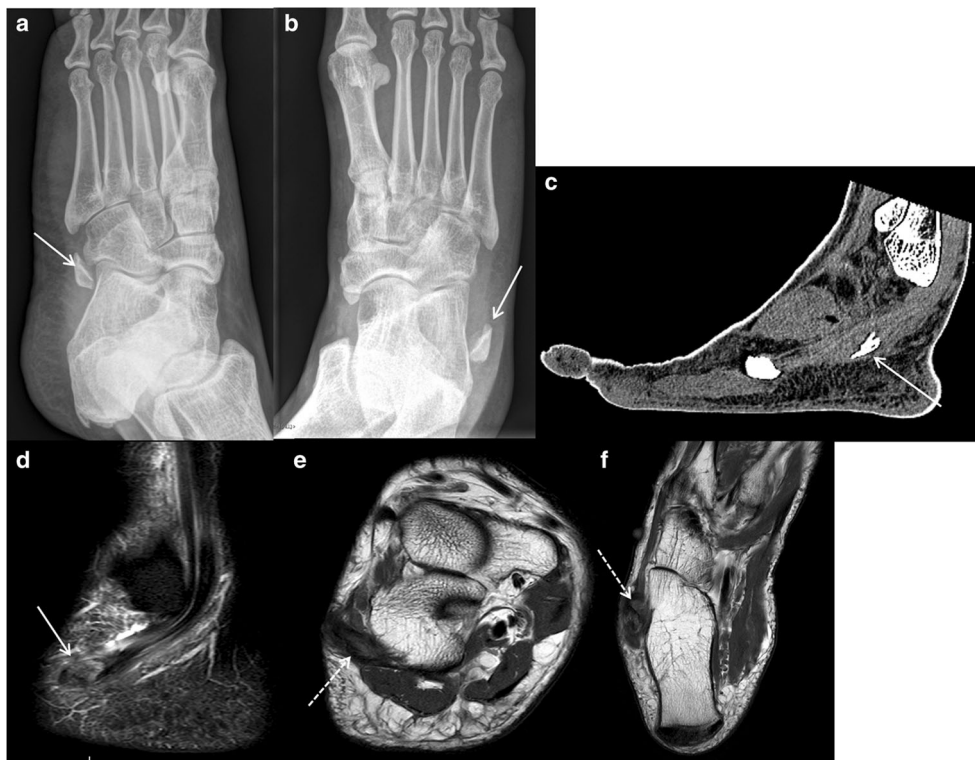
Frontal radiograph of the left foot (a) shows normal appearance and location of the os peroneum (arrow). Frontal radiograph of the right foot (b) shows retraction of the os peroneum (arrow). Sagittal CT (c) of the right foot confirms a well-corticated bony fragment embedded within a thickened peroneus longus tendon compatible with an os peroneum
